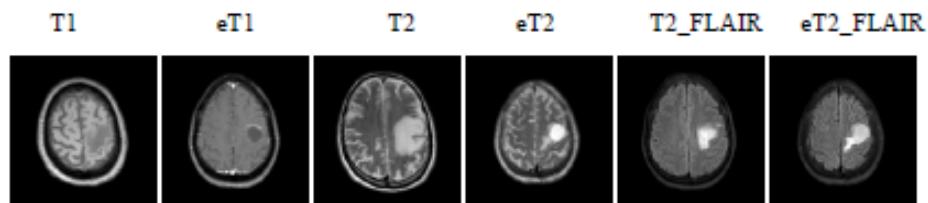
Axial MR images of different modalities.
